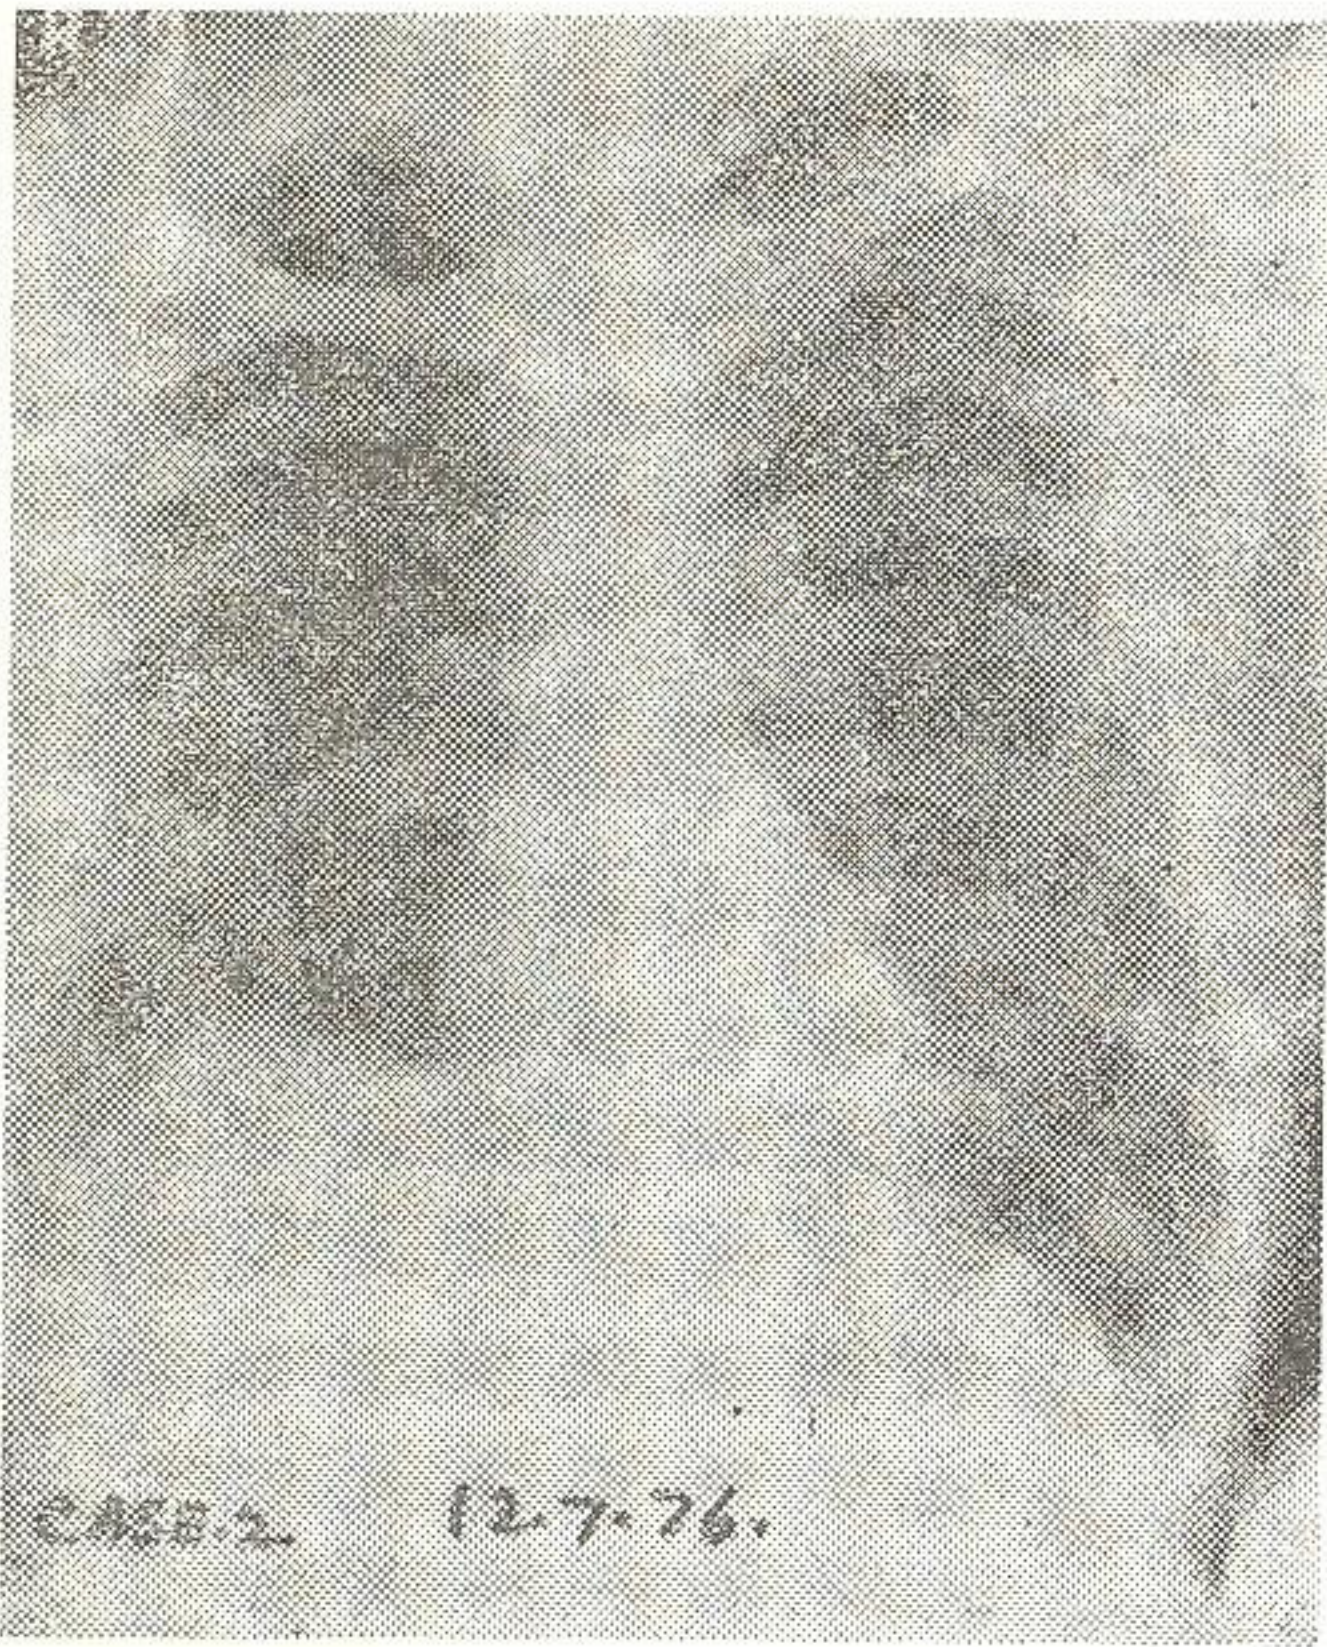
Case-2 (12-7-1976). X-Ray chest after antiamebic therapy. Right diaphragm is raised with pointed centre suggestive of underlying liver abscess.
